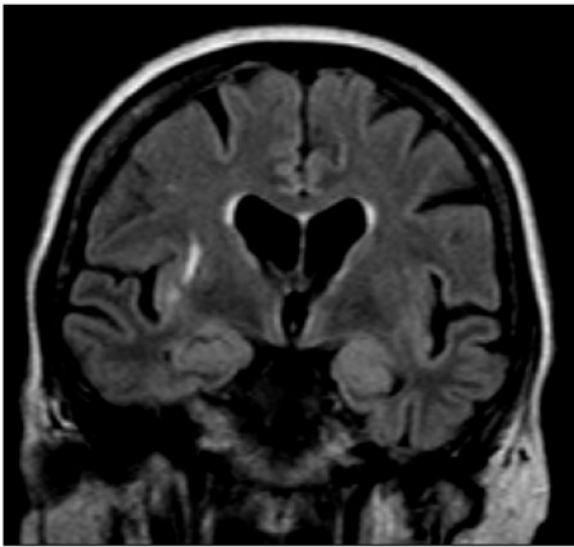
MRI FLAIR sequence coronal view of Case 3 showing bilateral high-signal changes in mesial temporal lobes and insular cortices.
